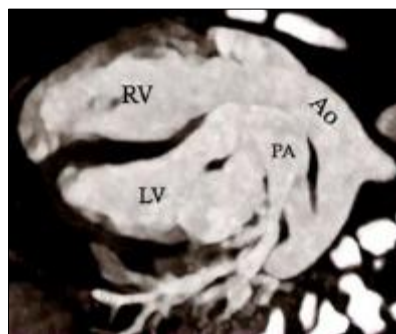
Cardiac CT image of TGA. D-TGA appearance at CT. Axial oblique reformatted maximum intensity projection image from cardiac CT angiography in a patient with D-TGA shows the LV connected to the main PA and the RV connected to the aorta (Ao)
